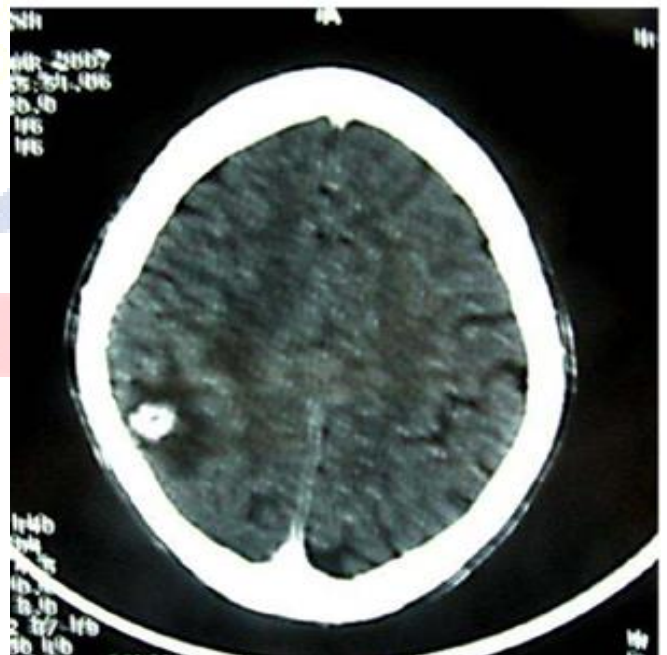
CT scan suggestive of tuberculoma
